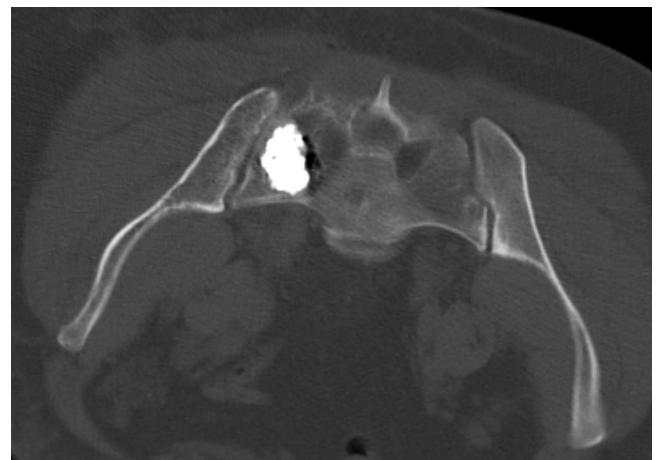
Computed tomographic image of the patient's sacrum after injection of the acrylic cement.
